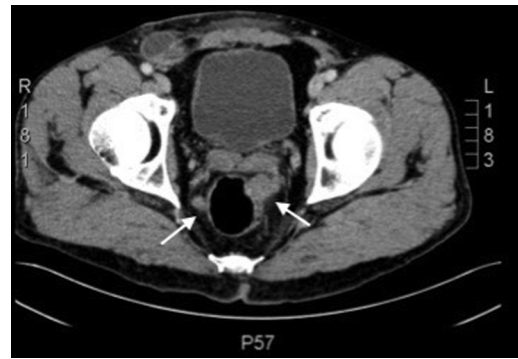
CT of the pelvis showing multiple peri-rectal nodules (white arrows).
